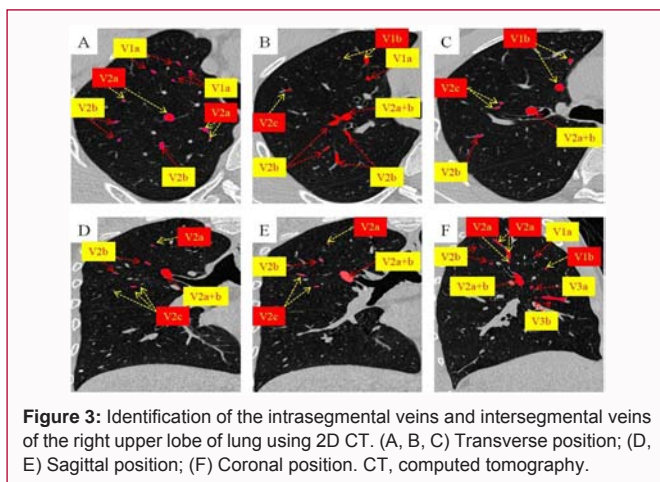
Identification of the intrasegmental veins and intersegmental veins of the right upper lobe of lung using 2D CT. (A, B, C) Transverse position; (D, E) Sagittal position; (F) Coronal position. CT, computed tomography.
